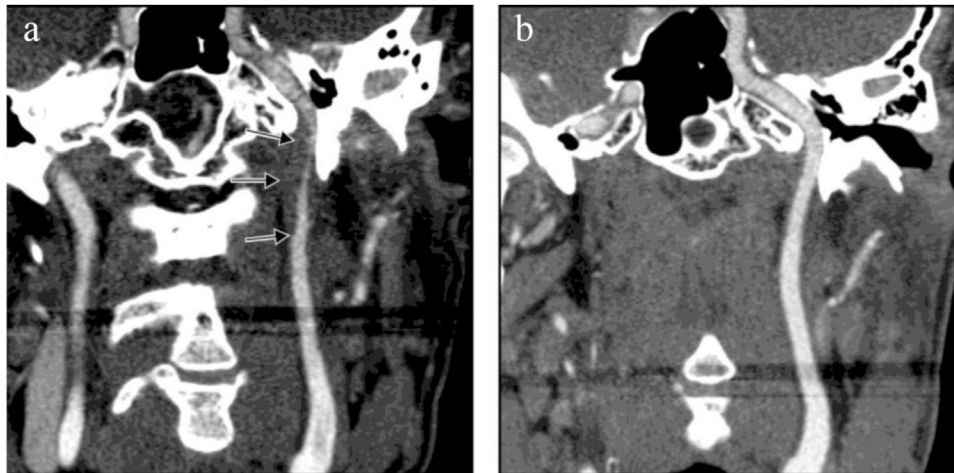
(a) CT angiography performed 5 days after admission revealed significant stenosis of LICA (the arrows indicate the extent of intramural hematoma). (b) Follow-up CT angiography 15 weeks after the first visit showed a near total reconstitution of LICA lumen.
